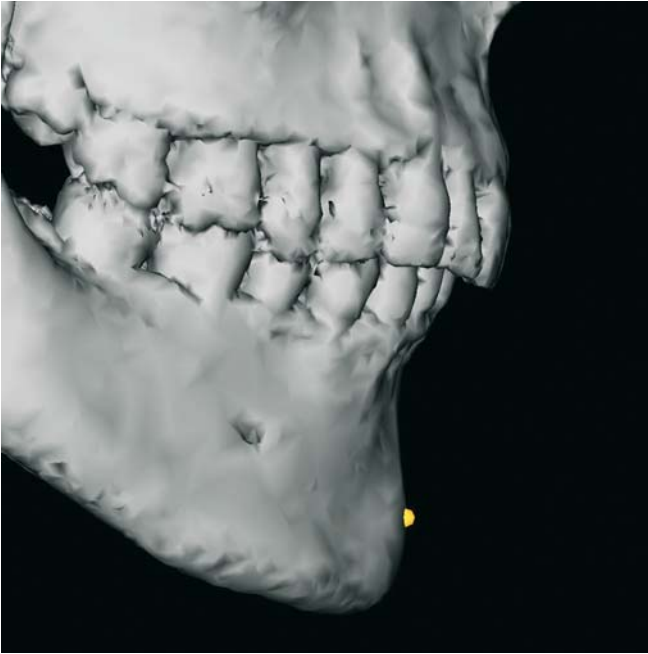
Pogonion. Profile view right (3-D CT, patient K.C.)
